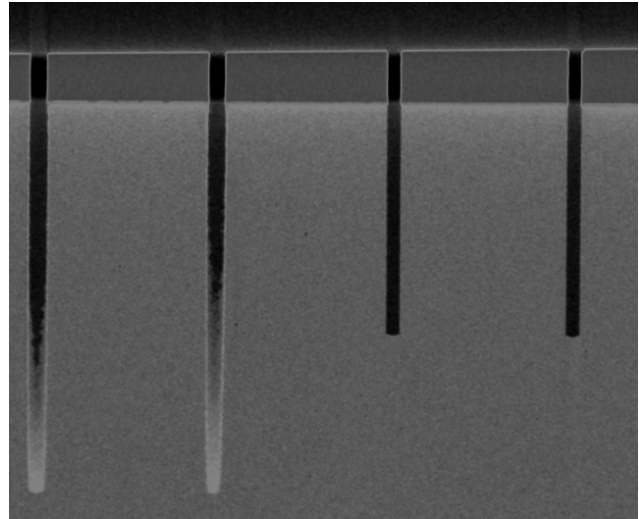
CT-image of the drilling channels. The two channels on the left are drilled with drill a) and the two on the right with drill b).
